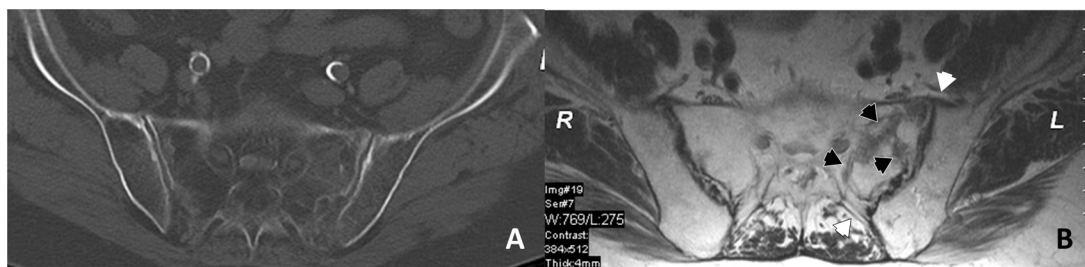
CT (A) and MRI (B) images of the sacrum of an 80 years old woman after a low-energy fall from a standing position. The fracture lines are better recognisable in the MRI.
